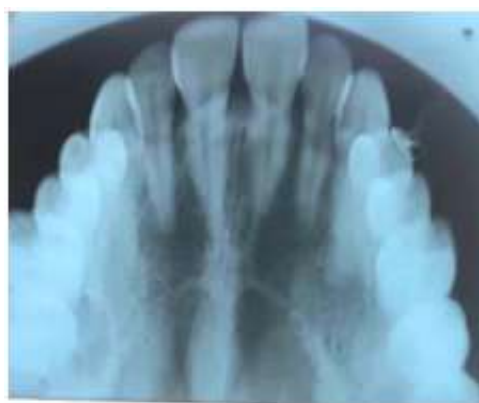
Shows occlusal radiograph.
